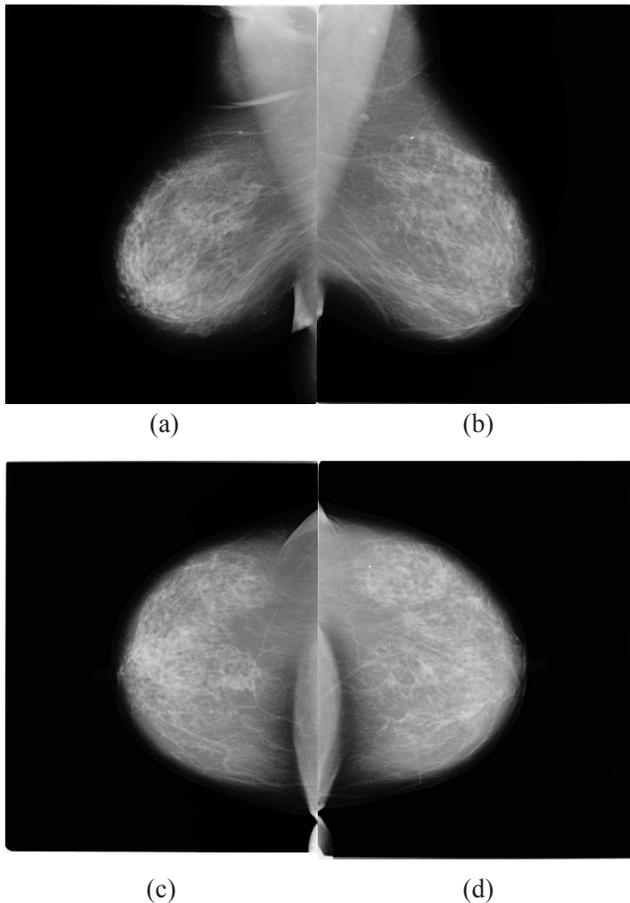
A 53-year-old woman. Mammograms in 2 standard planes: a, c – mammograms of a right breast in inclined and straight planes; b, d – mammograms of a left breast in inclined and straight planes. In the radiological report, MD of breast tissue is identified as ACR BI-RADS C; the radiologist has recommended to make an ultrasound scan. The category is stated incorrectly, MD of breast tissue of this patient corresponds to ACR BI-RADS B. That means that the patient has to undergo a routine and control mammographic exam with respect to her age.
